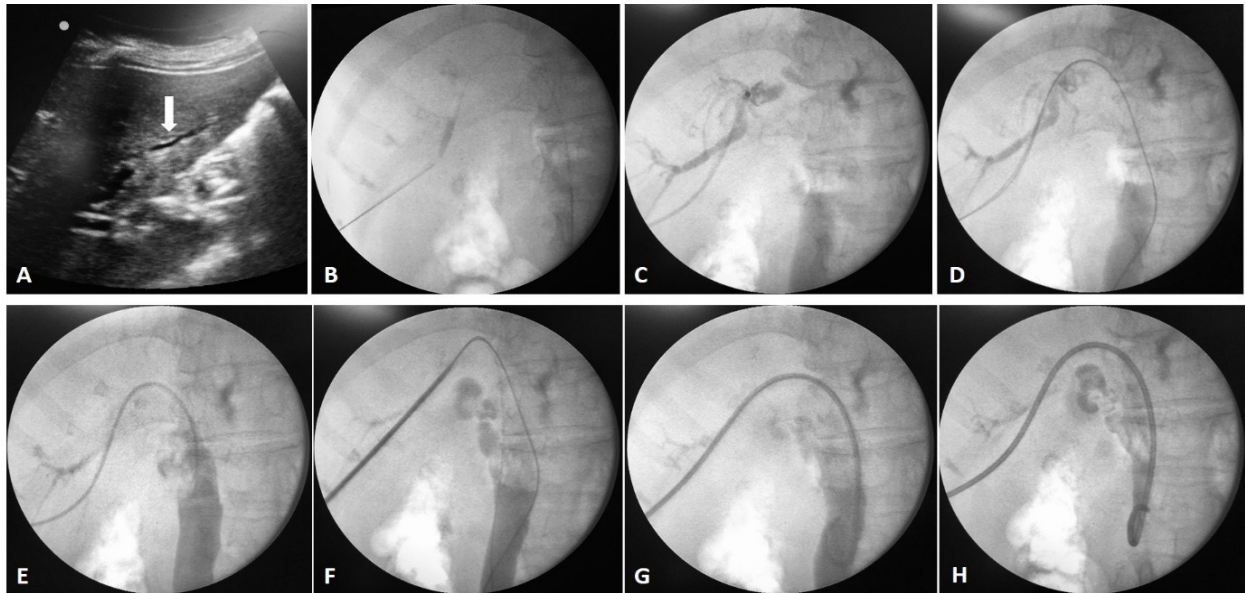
Pre-operative PTBD using Seldinger technique in a patient with ampullary cancer. (A) A segmental IHD dilatation was seen on ultrasound (arrow). (B) Ultrasound-guided puncture of the selected IHD. Contrast medium was injected to confirm the IHD and a 0.018" hair wire was advanced to the distal common bile duct (CBD) under fluoroscopic guidance. (C) A 5F sheath was introduced over the wire and cholangiography was performed to evaluate the biliary tree anatomy and pathologies. (D) A 0.035" J tip hydrophilic wire was manipulated across the obstruction site to the distal CBD followed by an introduction of an angiographic catheter. (E) Cholangiography of the downstream CBD was done. (F) The tract was dilated with an 8F dilator. (G) An 8F pigtail drainage catheter was advanced over the wire and positioned in the distal CBD. (H) Completion cholangiography and aspiration were performed to confirm the desired catheter position and function.
